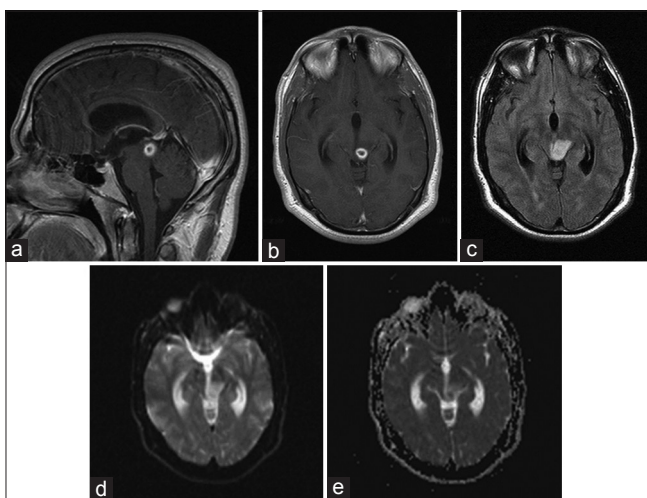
Initial MRI showing tectal ring enhancing mass. (a) Sagittal T1 with contrast; (b) Axial T1 with contrast; (c) Axial FLAIR showing surrounding edema; (d) Axial DWI; (e) Axial ADC
